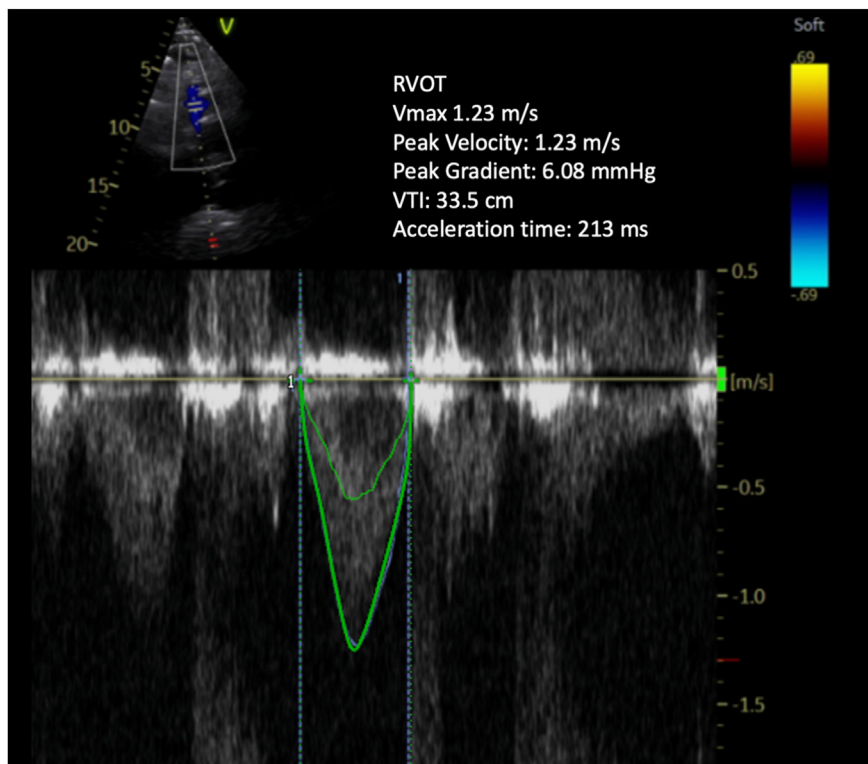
Two-dimensional TTE pulsed-wave Doppler tracing, parasternal short-axis view, demonstrates a normal RVOT velocity, indicating no subvalvular obstruction in the area interrogated.
